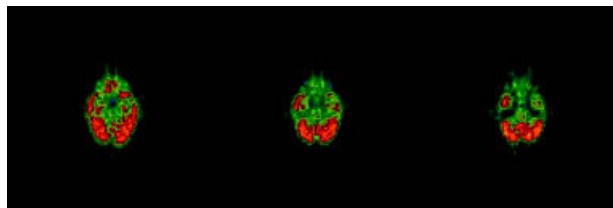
18 Fluorodeoxyglucose–positron emission tomography (18 FDG-PET) study demonstrates interictal hypometabolism in multiple areas (medial and lateral left temporal, medial right temporal) in a patient with epilepsy in the medial temporal/limbic network.
